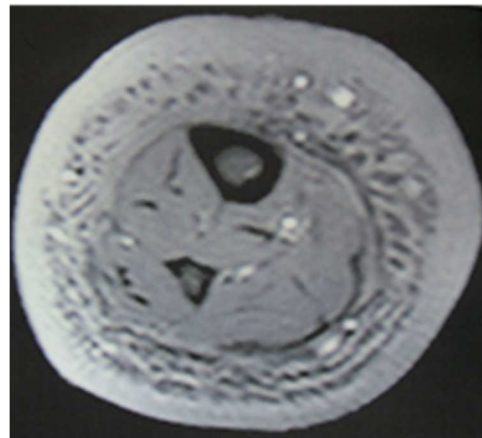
Transaxial MR image of the left leg showing marked thickening in the skin and subcutaneous tissue.
